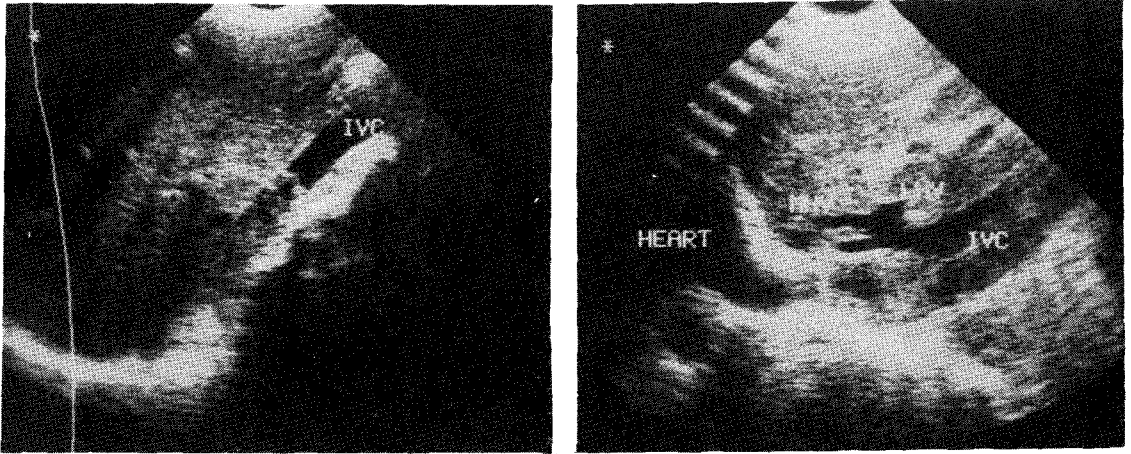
Ultrasonographic findings showing echogenic mass in IVC extending up to right atrium & dilated branches of hepatic vein (MHV: middle hepatic vein, LHV: left hepatic vein)
